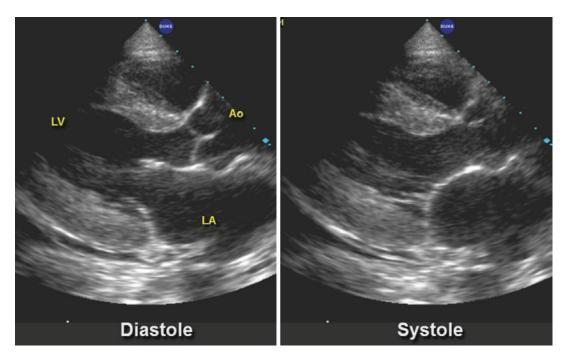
Parasternal long axes in diastole (left panel) and systole (right panel) in a patient being followed for chronic renal failure and malignant hypertension. Despite
